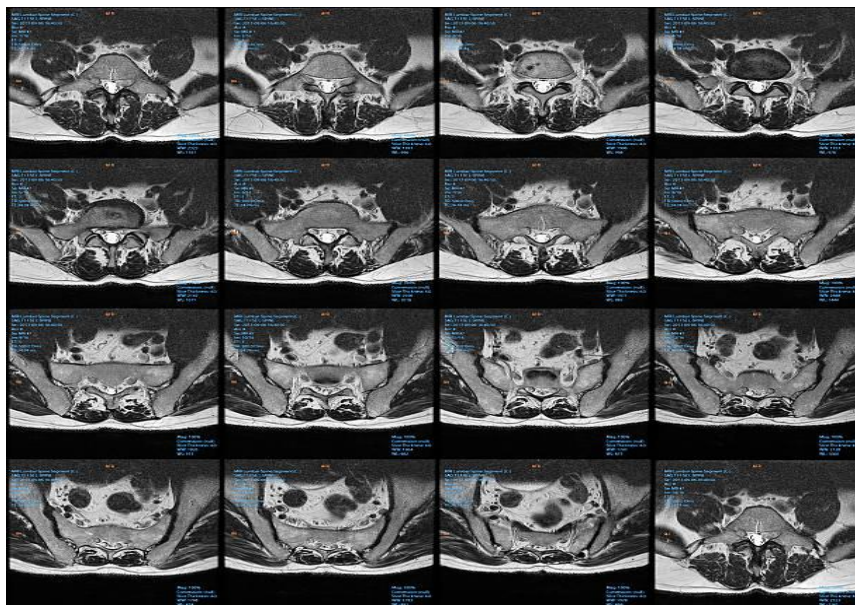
PICTURE SHOWING FIBROIDS IN MRI
